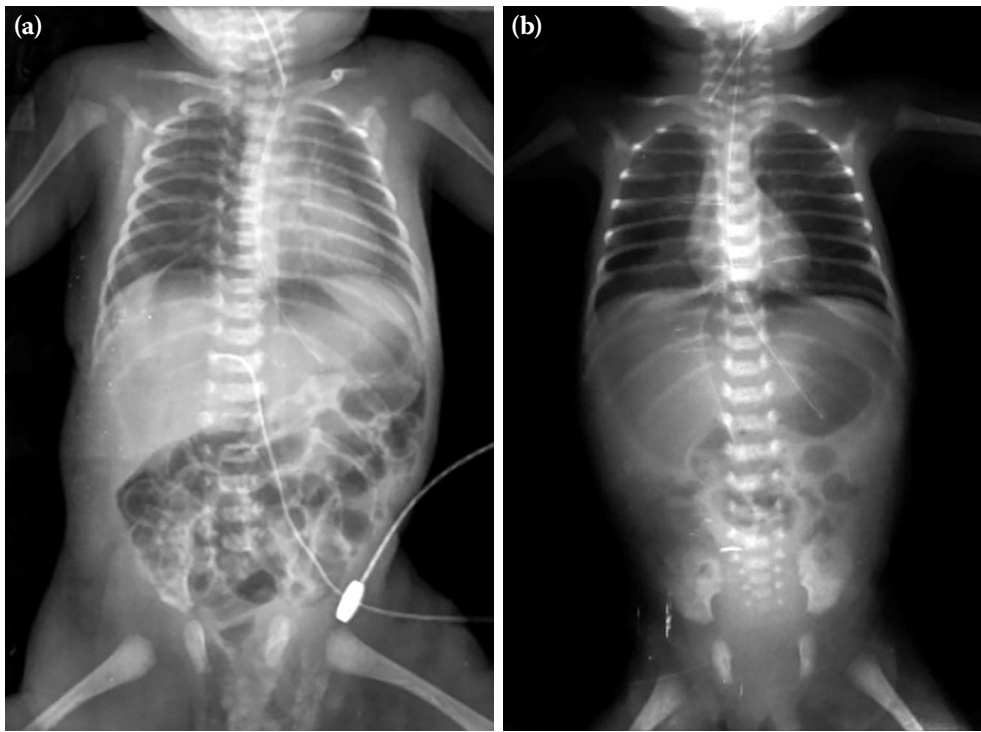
Suspected subdiaphragmatic free air on standing abdominal X-ray. (a) First case. (b) Third case.
